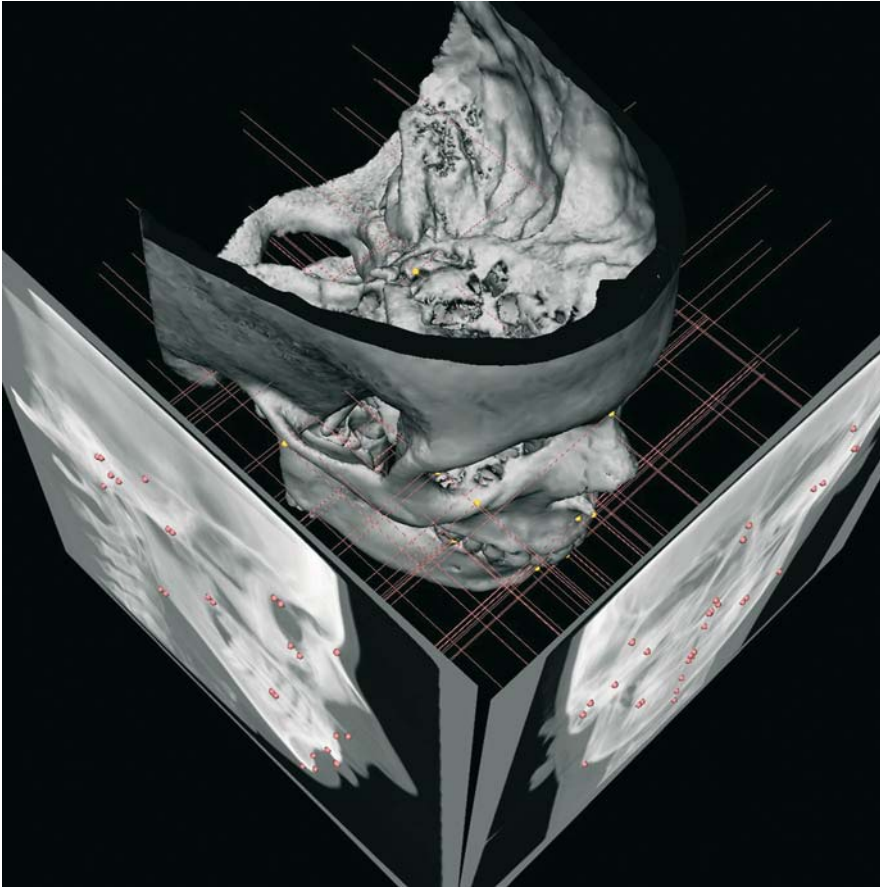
Set-up of 3-D cephalometric hard tissue landmarks. Virtual lateral and frontal cephalograms linked to the 3-D hard tissue surface representation (3-D CT, patient K.C.)
